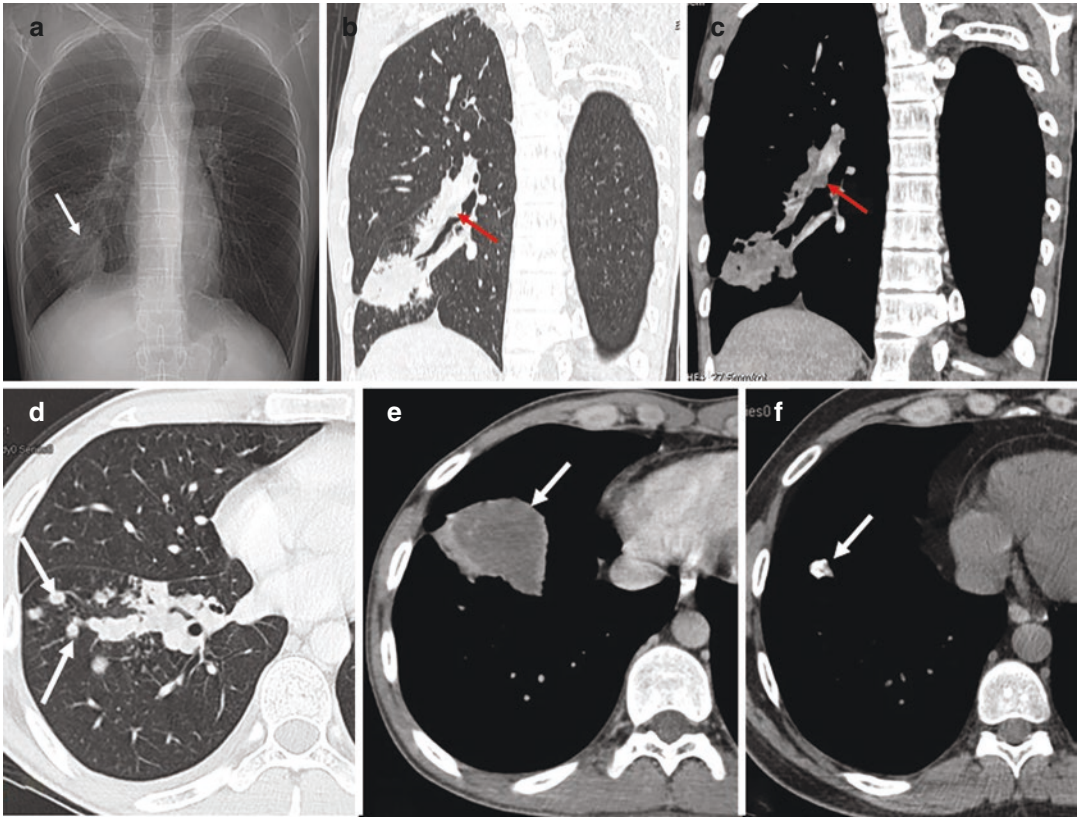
Tumorlike tuberculosis in a 23-year-old man who presented with chest pain. (a) PA chest radiograph shows a rounded right lower zone opacity (white arrow). (b and c) Coronal and (d and e) axial CT images show an endobronchial mass (red arrows in b and c), pulmonary
